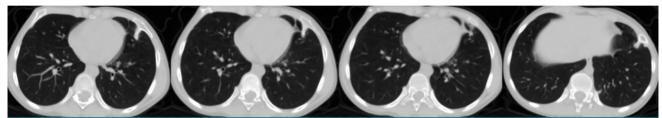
Thoracic CT image of a 12-year-old male patient demonstrating multiple pedunculated paracardiac osteochondromas. CT: Computed tomography.
